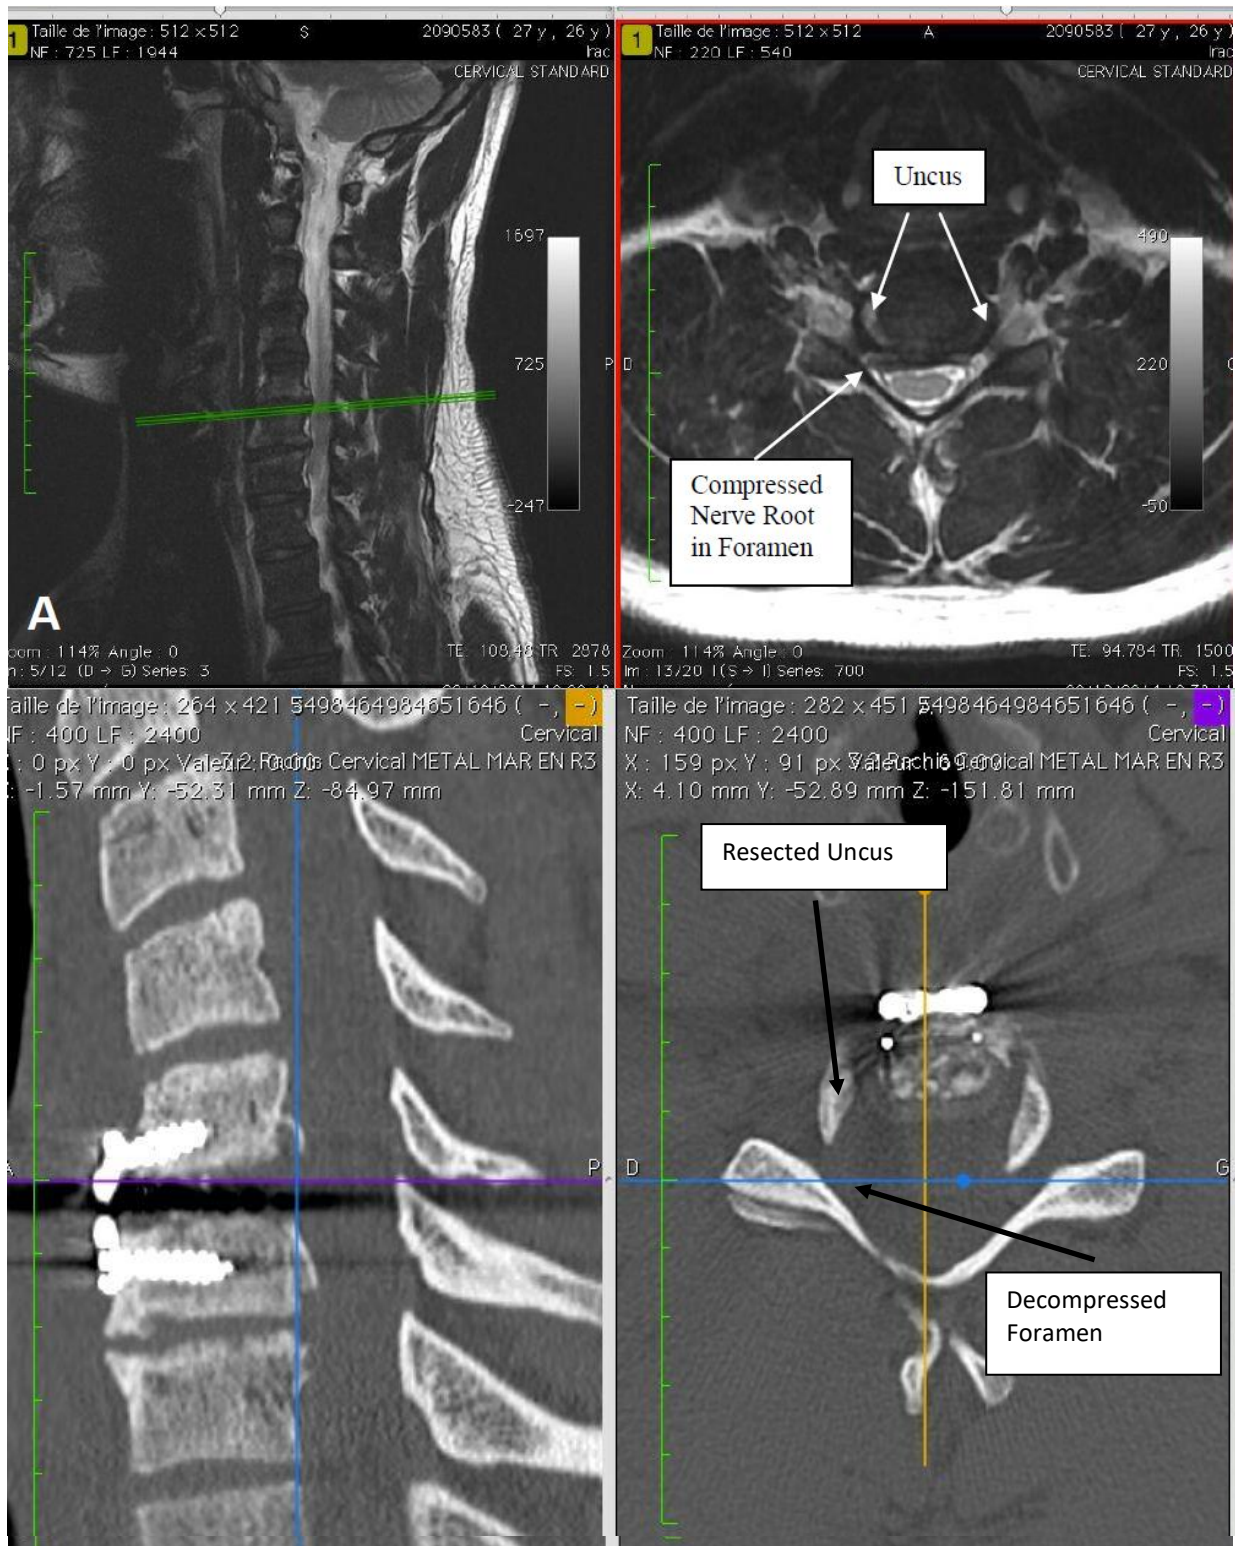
A) Pre-op lateral and axial MRI for a patient with right sided nerve root compression (Patient No 10). B) Post-op CT scan demonstrating resection of uncus and decompressed foramen
